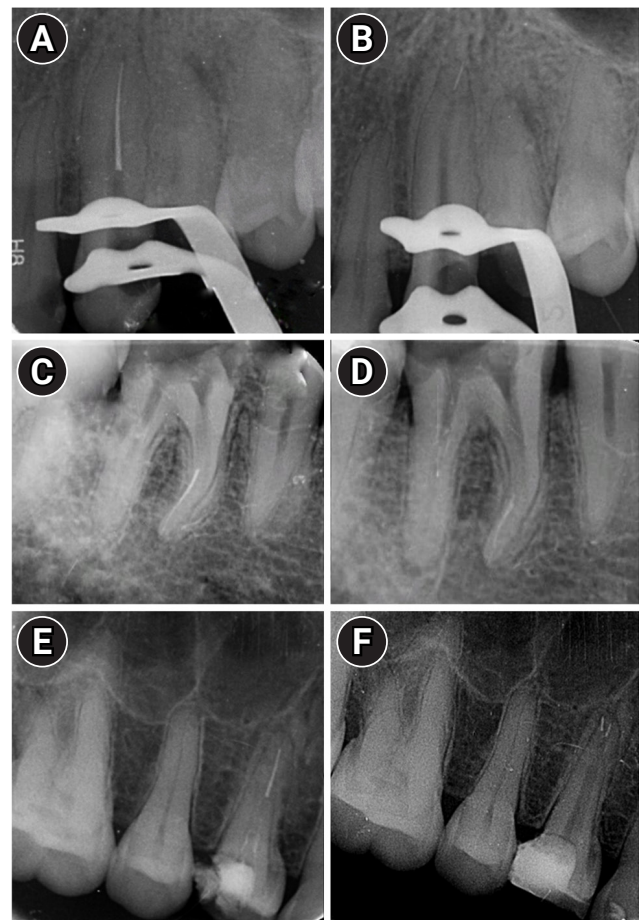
(A) Separated instrument in apical two-thirds. (B) Secondary fracture of the separated instrument. (C) Separated instrument in the apical third. (D) Separated instrument with lateral strip perforation, (E) Separated instrument in the apical third. (F) Secondary fracture of the separated instrument and lateral perforation.
